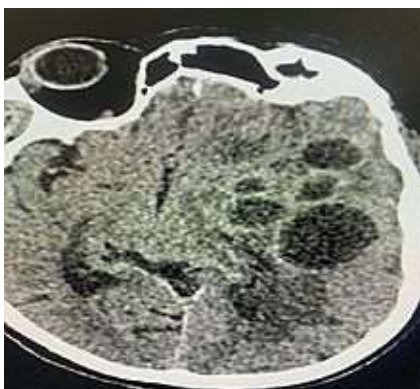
CT brain showing multiple thin-walled hypo-dense lesions with peripheral iso-dense rim at left sub-thalamus and temporal region with surrounding edema causing midline shift to right.
